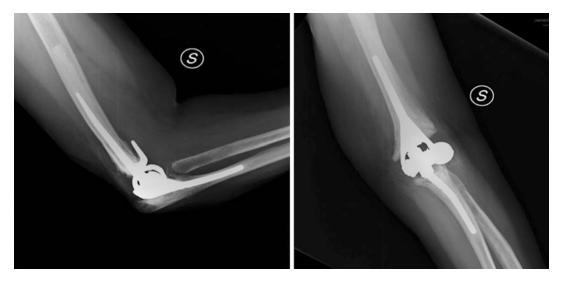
Post-op X-rays of type 1 bone loss
